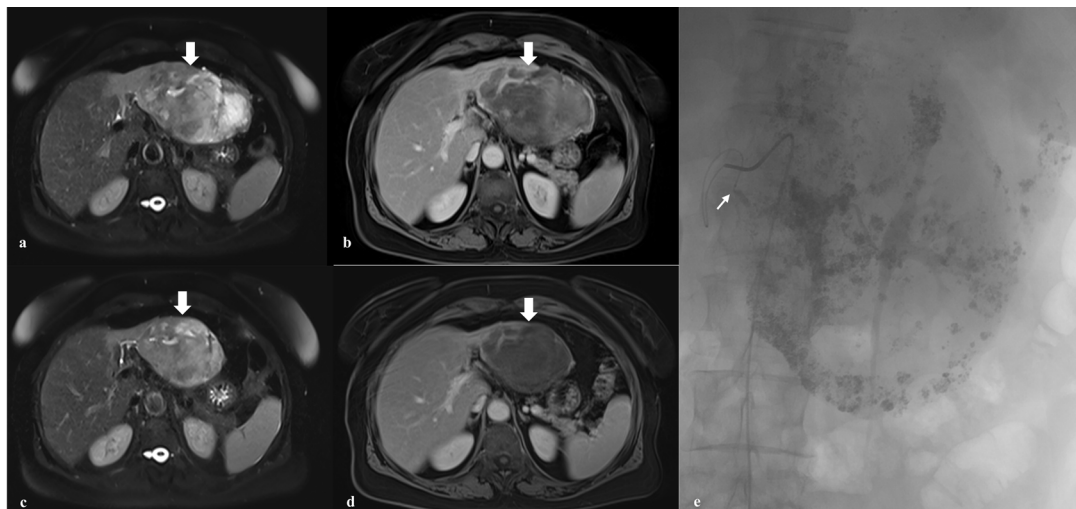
A patient presenting with right hypochondrial pain was found to have a lesion in the right lobe of the liver, indicated by the thick white arrow. Following the procedure, the patient's symptoms improved. A) Preoperative axial T2-weighted image. B) Preoperative axial contrast-enhanced T1-weighted image. C) Postoperative axial T2-weighted image. D) Postoperative axial contrast-enhanced T1-weighted image. C, D) Postoperative images demonstrate a marked reduction in lesion size. E) Angiographic image showing complete embolization of the lesion through a super-selective microcatheter approach (thin black arrow), using a bleomycin-lipiodol mixture delivered into the feeding artery
